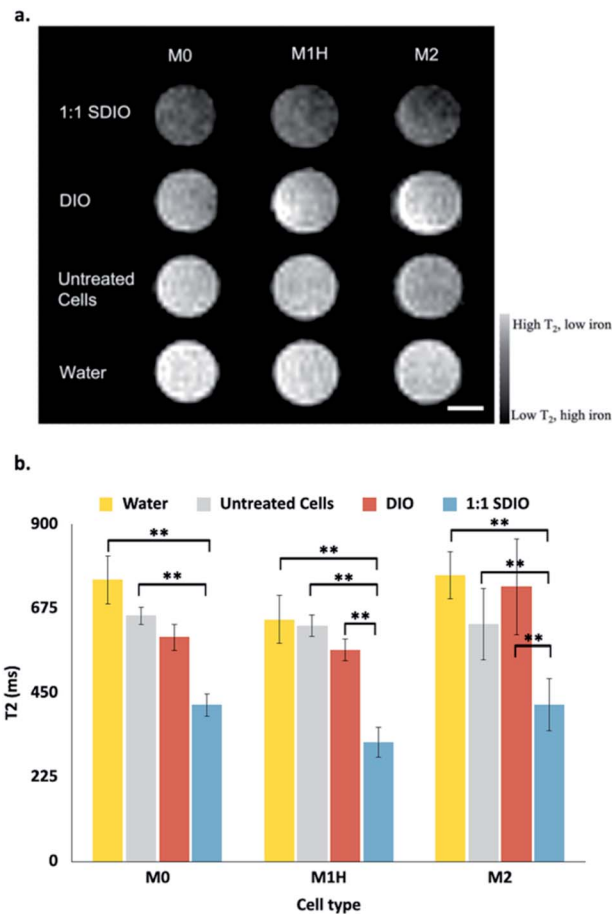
Representative reconstituted MR images of BMDMs lysates (a) and mean T2 values (b). Samples containing reconstituted cell lysate samples from different macrophages subtype incubated with 1 : 1 SDIO (top row), DIO (2nd row), media only (3rd row), and a reference of pure water (bottom row). ( $n = 3$ ) All three subtypes of macrophage incubated with 1 : 1 SDIO showed the highest signal suppression characteristic of T2 agents (darker images), while DIO incubated cells and untreated cells were similar to pure water. Scale bar = 4 mm. The average T2 values ( $n = 3$ ) were reported in panel b with standard deviation as the error bar. The differences were considered significant with  $P$  values \*  $< 0.05$ , \*\*  $< 0.01$ , and \*\*\*  $< 0.001$  as shown.  $P$  values are corrected for multiple comparisons within a given outcome with the post hoc Tukey HSD correction.
